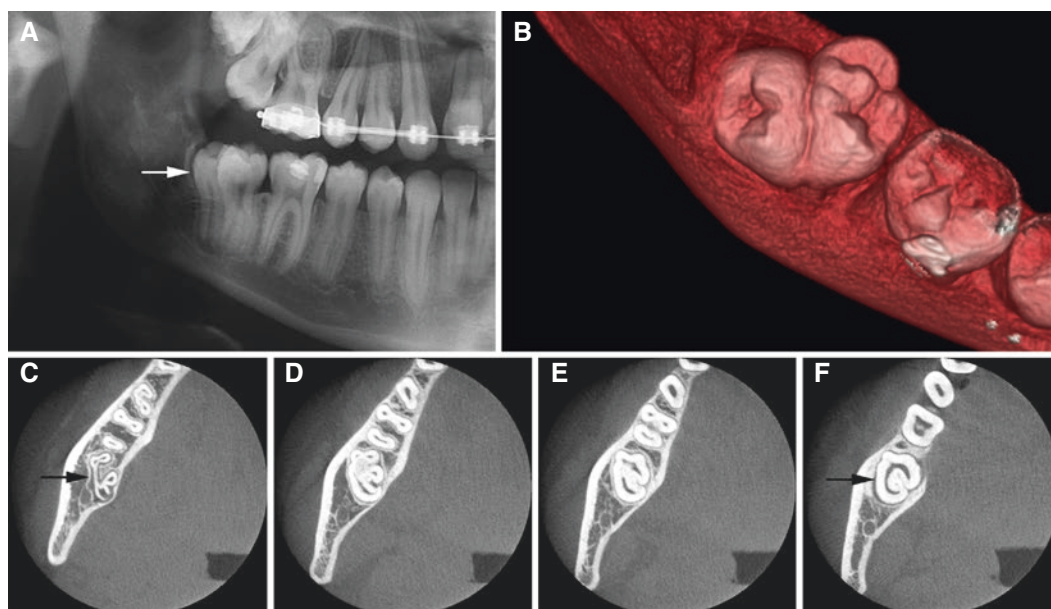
“Double tooth,” mandible; 15-year-old female. (A) Panoramic view suggests “double molar” (arrow). (B) 3D and (C, D, E, F) axial CBCT images show complete fusion (crown and root) of the second and third molars (arrow)
